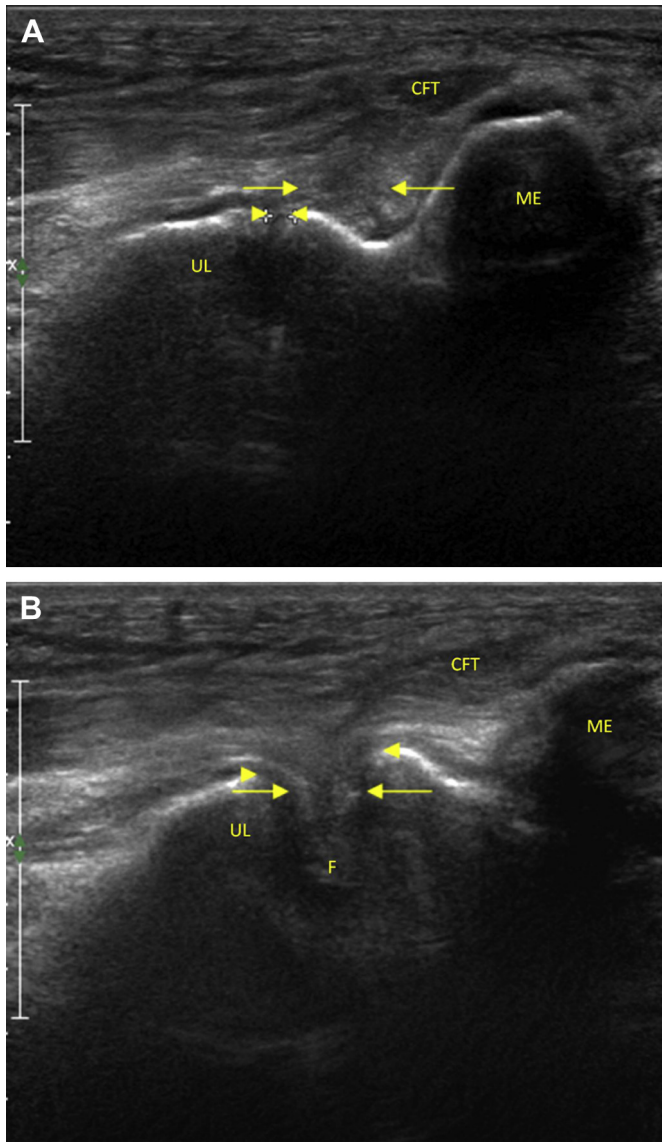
Initial coronal ultrasound scan through the medial aspect of the elbow. (A) At rest, the elbow joint shows a small area of heterogeneous hypoechogenicity in the medial collateral ligament (arrows). The joint space was 2.3 mm (arrowheads). (B) Under valgus stress, the elbow joint shows some echogenic fat (heterogeneous hyperechogenicity) (arrows) herniated into the joint with widening of the joint space. The joint space was increased to 6.3 mm (between arrowheads). CFT = common flexor tendon; F = fat herniation; ME = medial epicondyle; UL = ulnar bone.
